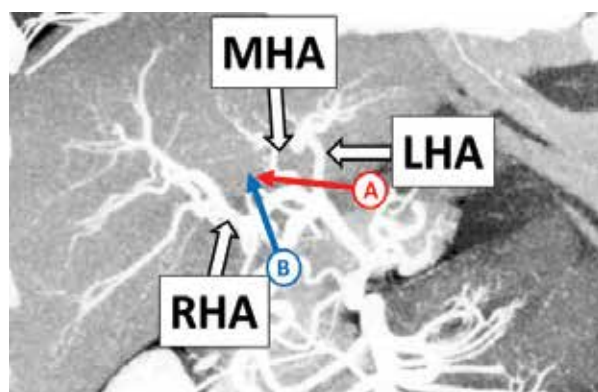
The results of a CT angiographic examination of a donor. The arrow (A) indicates the dividing point of the middle and left hepatic arteries when the left lobe graft is selected, while the arrow (B) indicates the dividing point of the right hepatic artery. LHA, left hepatic artery; MHA, middle hepatic artery; RHA, right hepatic artery
